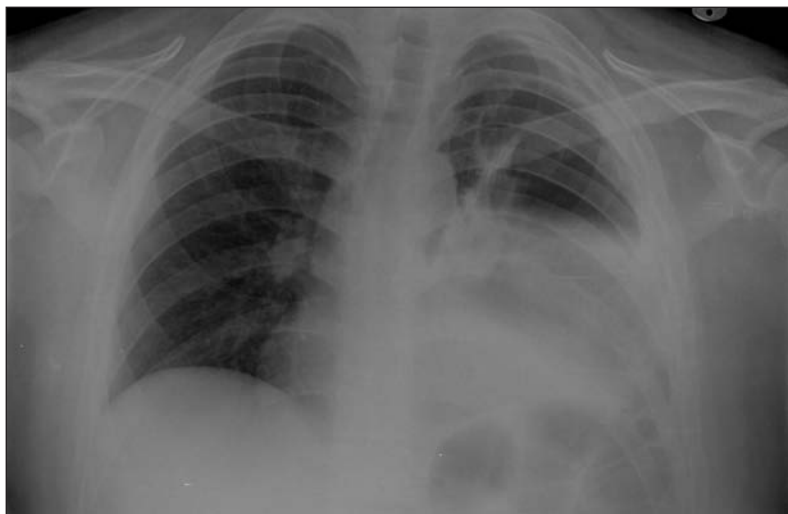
A portable chest radiograph showing a large, left-sided pleural effusion.
